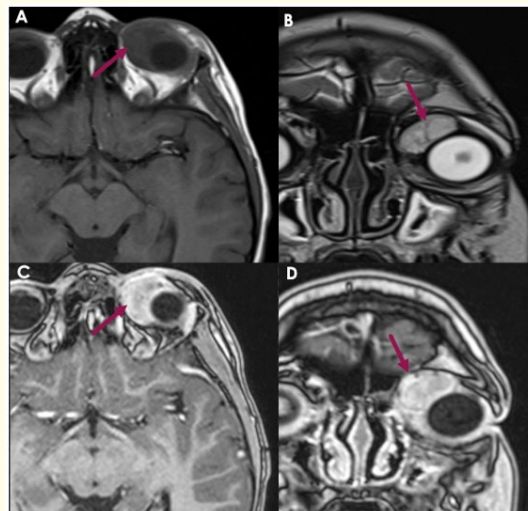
Orbito-cerebral MRI comprising axial T1-weighted (A), coronal T2-weighted (B) images, axial (C) and coronal (D) images post-Gadolinium injection, reveals a left superior extraconal mass, originating from the superior rectus muscle. It appears isointense on T1-weighted images, exhibits a high T2-weighted signal, with heterogeneous Gadolinium enhancement. The invasion is notable into the superior oblique muscle, extraconal fat, and ipsilateral subcutaneous palpebral soft tissue. Note the absence of invasion or mass effect on the eyeball or the optic nerve, nor any indication of intracranial extension.
